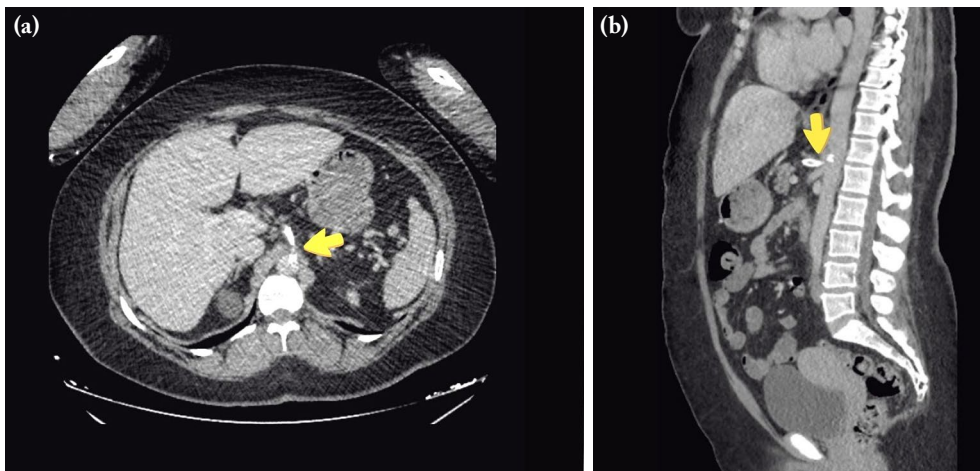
(a) One week after endovascular stent placement, computed tomography angiography (transverse section) shows that the stent is broken and thrombosed (yellow arrow); (b) computed tomography angiography (coronal section) shows that the stent is broken and thrombosed (yellow arrow).
